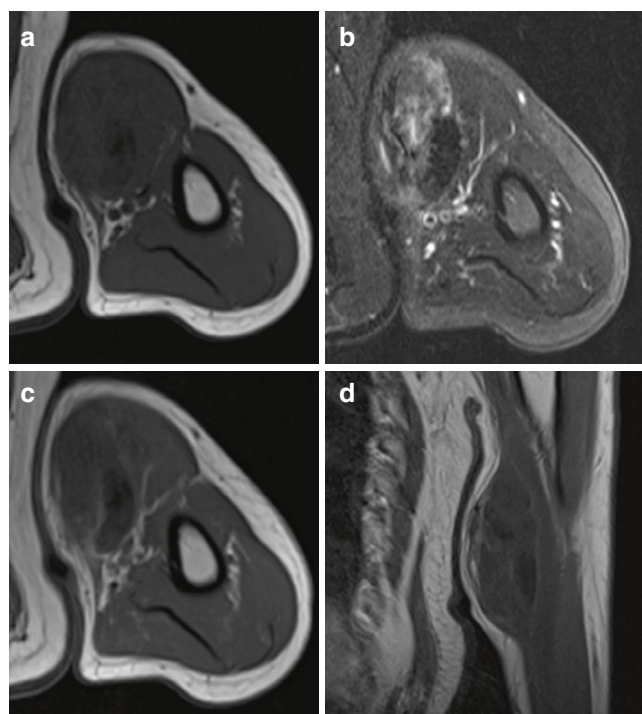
MRI images after neoadjuvant treatment showed a clear reduction in the size—measured $7 \times 5 \times 2.1$ cm—and a change in the characteristics of the mass with a hypointense foci on T1-weighted sequences (a) and fat-suppressed T2-weighted sequences corresponding to hemosiderin deposits secondary to bleeding. In these sequences, a decrease in the cellular component is also observed, which leads to a decrease in the mass signal (b). After the administration of paramagnetic contrast, the mass showed discrete enhancement (c). Sagittal T1-weighted MRI and paramagnetic contrast: the enhancing tails have disappeared (d). According to RECIST criteria, there was a partial response: $>30\%$ decrease in longest axis measurement, no new lesions
